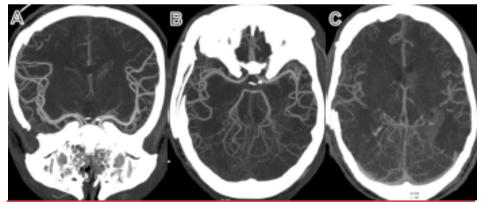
Patient 24, presenting mydriatic no reactive pupils. CTA performed 30 hours prior to clinical assessment because of thiopental use, with evidence of arterial (A and B) and venous (C) flow. Clinical assessment and TCD performed concomitantly were positive for BD.
